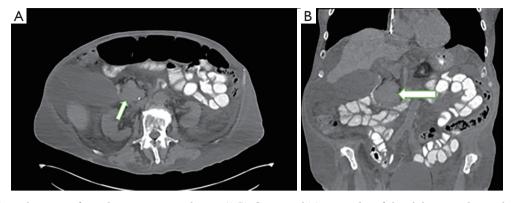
Radiological images of gangliocytic paraganglioma. (A,B) Computed Tomography of the abdomen/pelvis with oral and without intravenous contrast demonstrating a soft tissue density (white arrow) measuring $5.1 \text{ cm} \times 4.5 \text{ cm} \times 4.1 \text{ cm}$, unclear origin from the duodenum or pancreatic head. (A) Axial view. (B) Coronal view.
